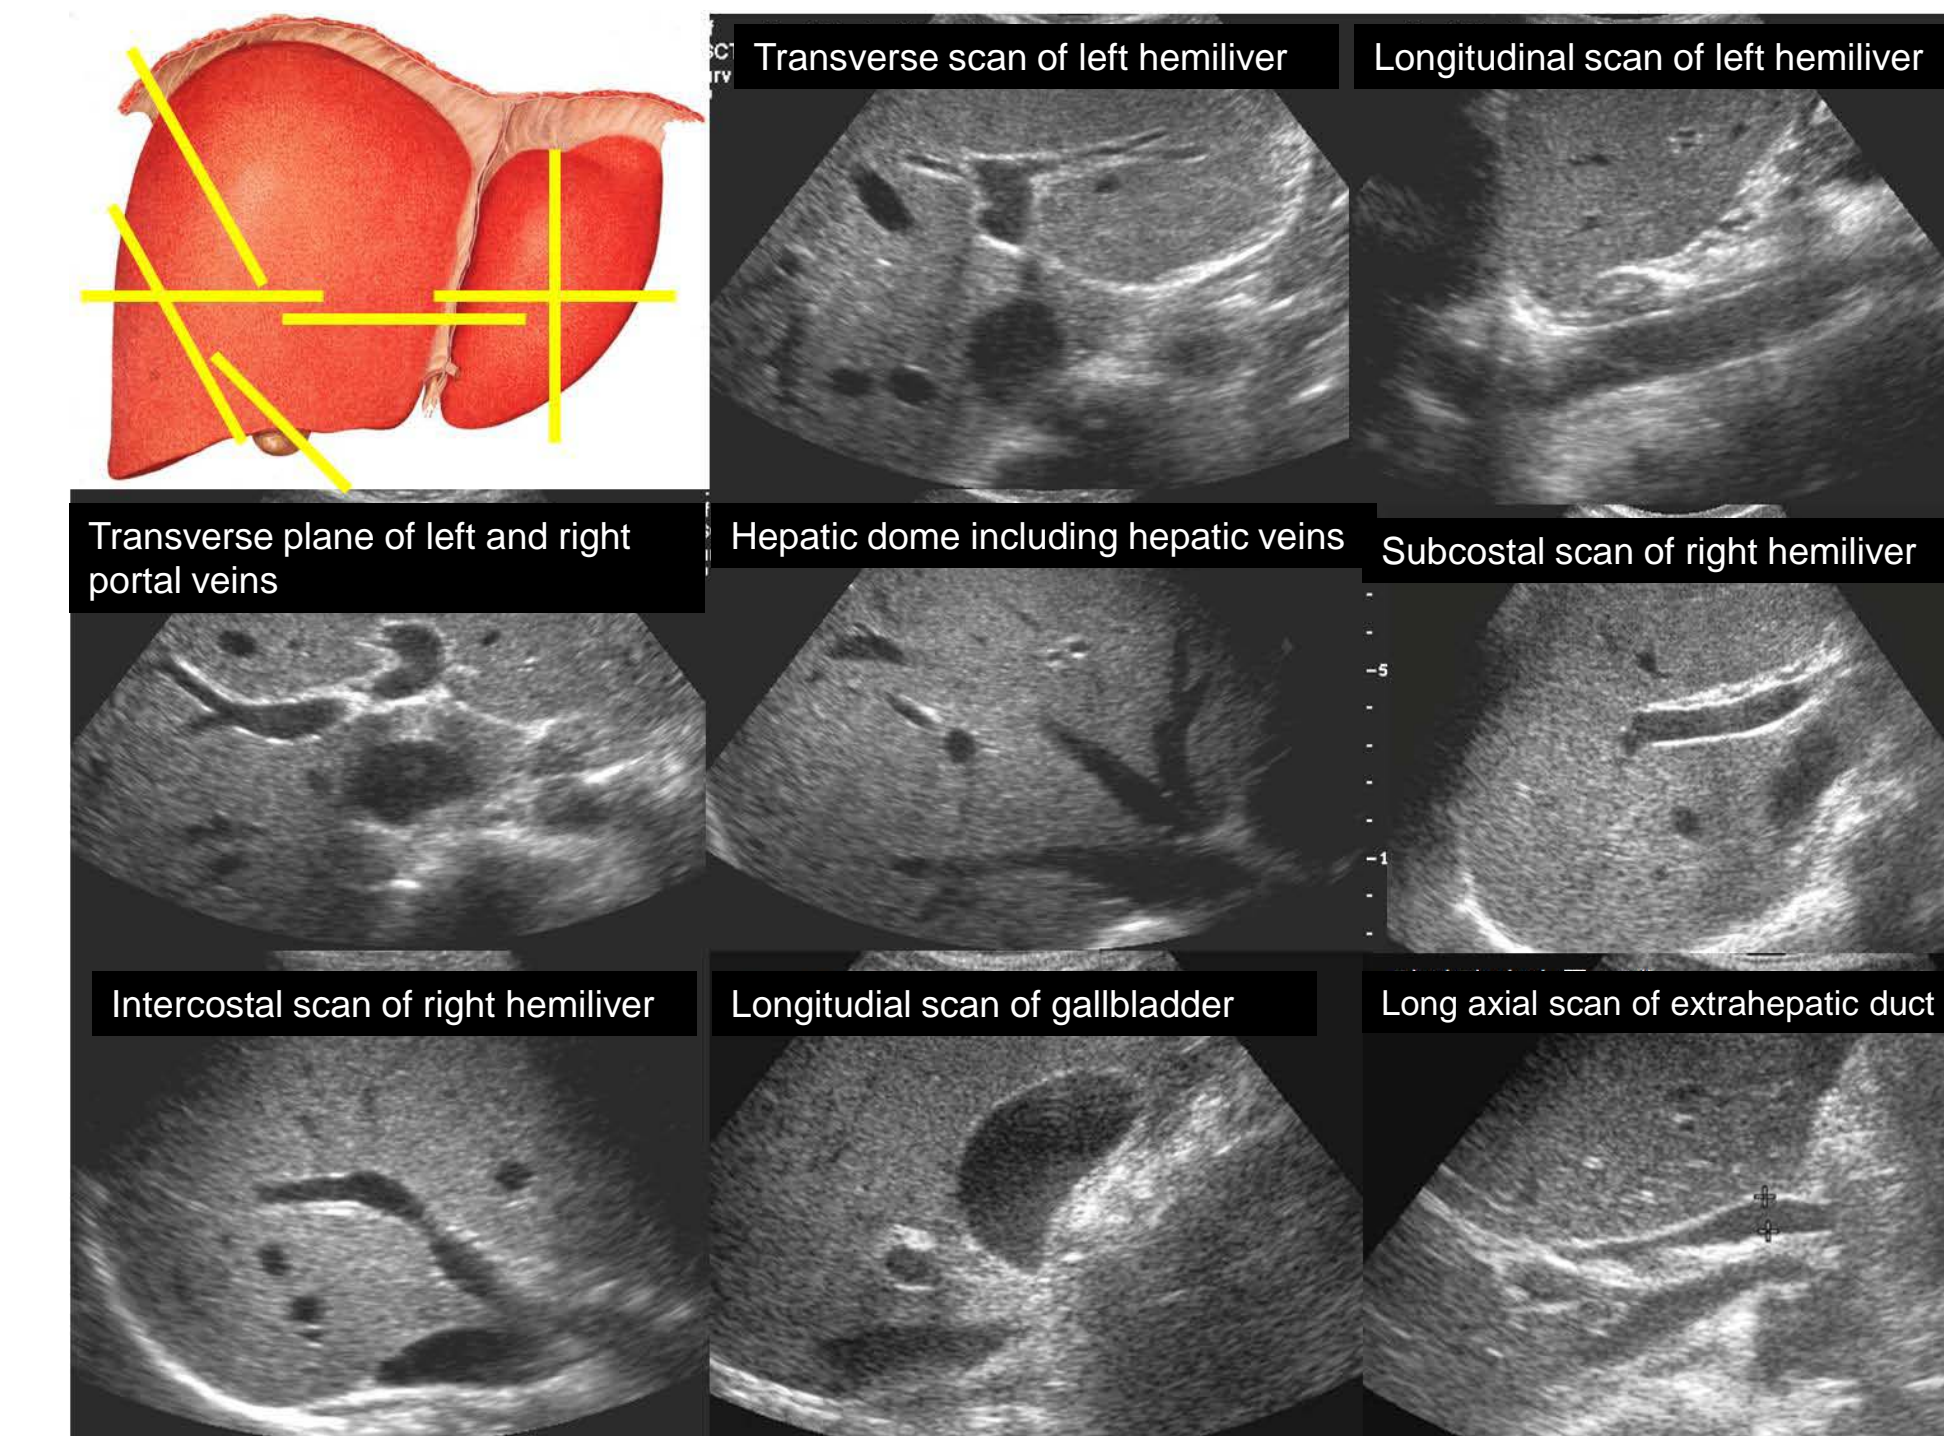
Eight standard images of the clinical image evaluation based on standard US protocol by the Korean Society of Radiology and the Korean Society of Ultrasound in Medicine.
